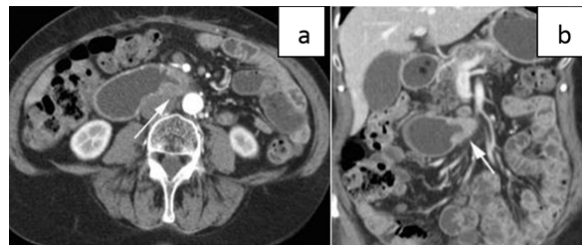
(a) Axial and (b) coronal CT images show wall thickening of the horizontal part of the duodenum (arrow) causing stenosis proved to be Duodenal adenocarcinoma.
